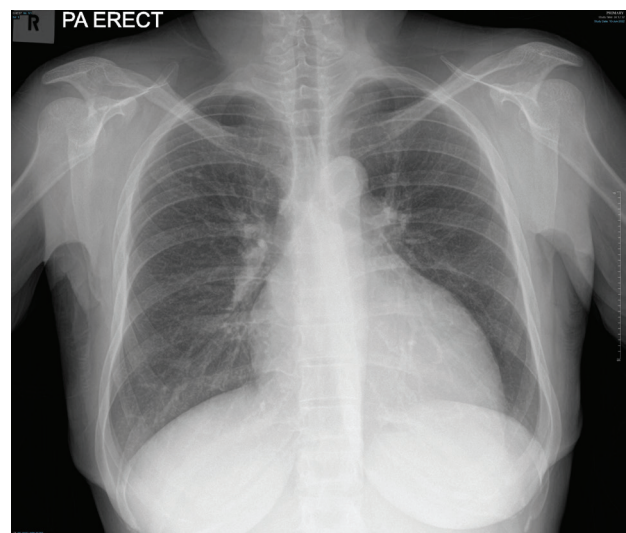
Chest-ray. Chest radiograph showed no air under the diaphragm.
